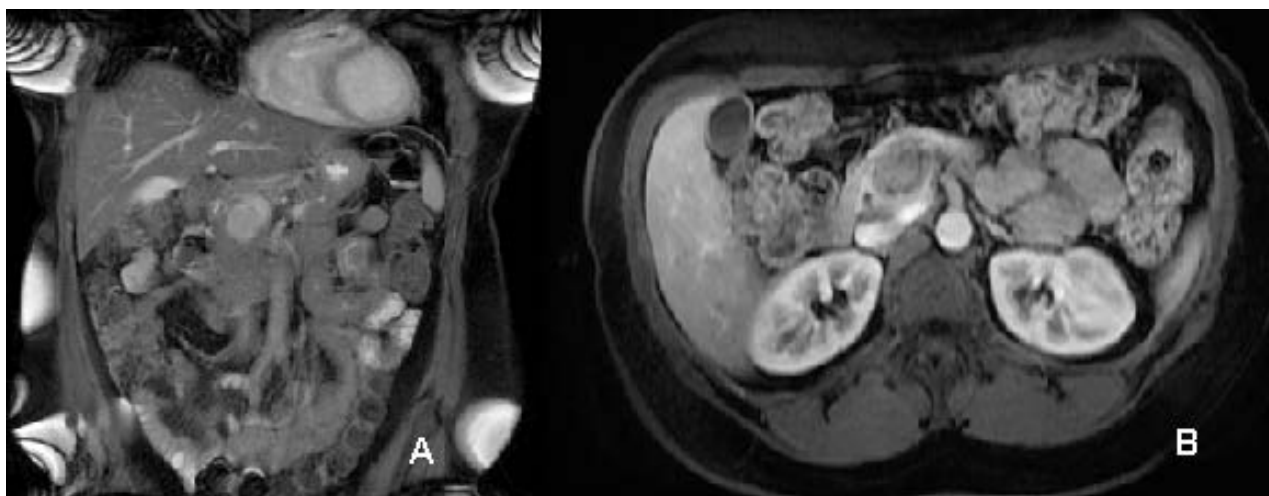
2015 MRI. Coronal section, T2-weighted, shows solid-cystic lesion, with hypersignal in T2, well delimited, in the head/uncinate process of the pancreas (A). Axial cut, T1-weighted after contrast, characterizing heterogeneous post-contrast enhancement (B).
